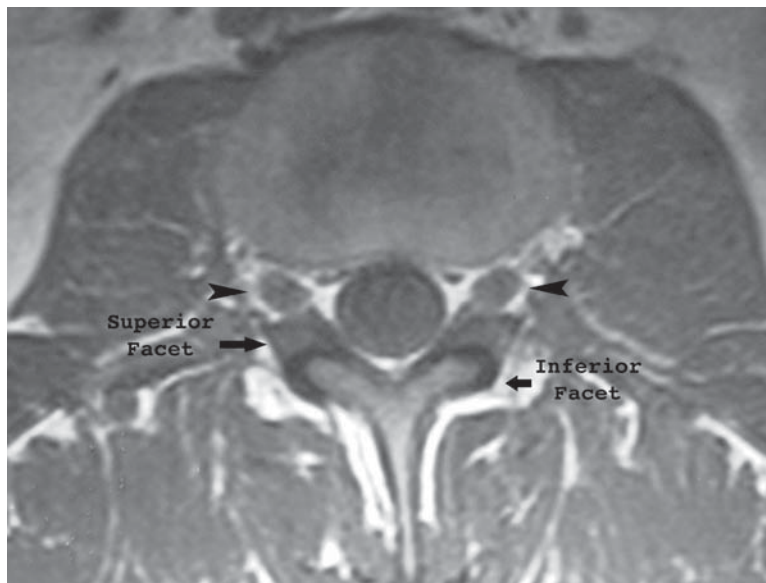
Axial MRI. The superior facet lies more anterior with the nerve root exiting between the facet and the lateral annulus (*Arrowhead: nerve root*).
